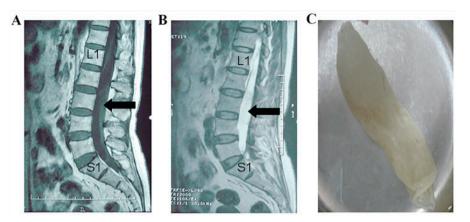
MRI detected a 16-cm cystic mass on L2 to S1. The MRI signal intensity of the lesion was high in the (A) T2-weighted image and low in the (B) T1-weighted image. (C) Intraoperative image of the white/cream colored mucoid cysticerci that was removed. The arrow indicates the cystic mass. MRI, magnetic resonance imaging.
